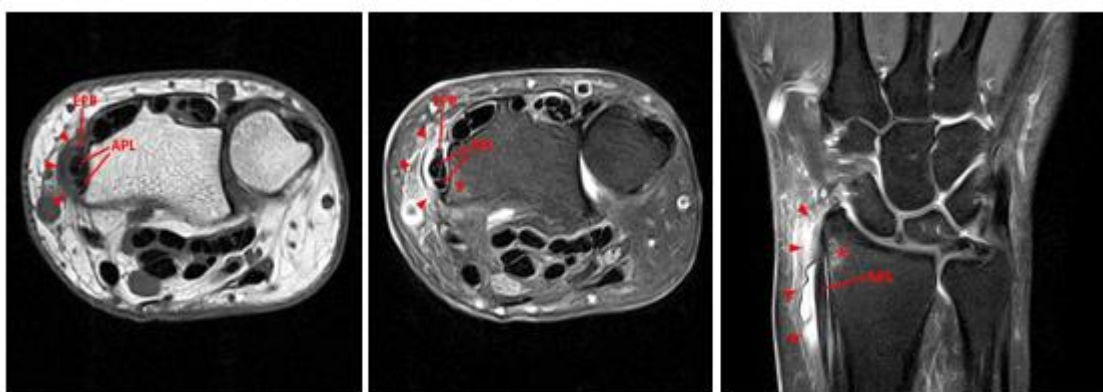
The Axial T1-weighted, Axial PD fat-suppressed weighted, and Coronal PD fat-suppressed weighted images demonstrate a thickened extensor retinaculum, surrounding soft tissue edema, and fluid signal in the first extensor compartment of the wrist (arrowheads). Marrow edema is noted within the subjacent radius (asterisks). A single extensor pollicis brevis and two abductor pollicis longus tendon slips are present with heterogeneous intrinsic signal. These findings are consistent with De Quervain's tenosynovitis.
